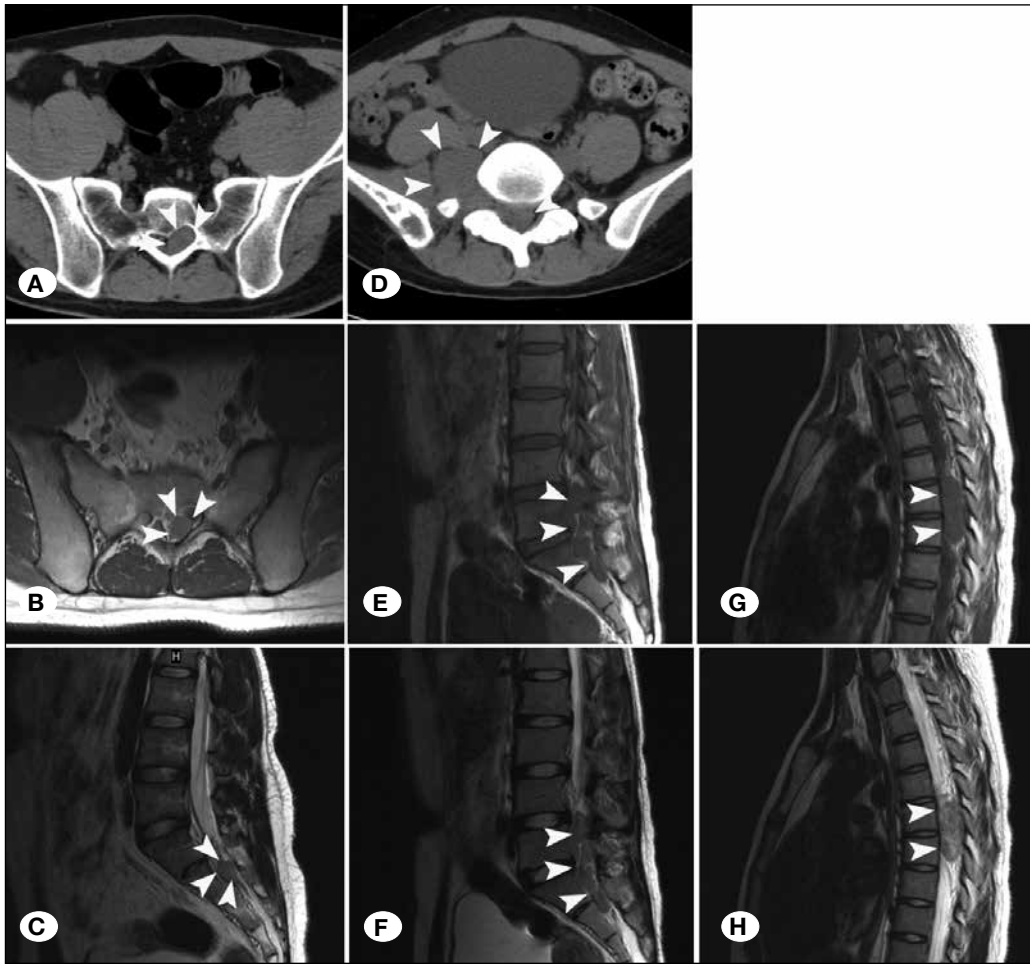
A) spPNET mass usually presents as an iso-dense mass on CT, an isointense signal on T1-WI, and a heterogeneous hyperintense signal on T2-WI. A, B, C) One extradural lesion (Case 2) at the S1 vertebral level (arrowheads). D, E, F) One intradural extramedullary lesion (Case 3) at the L5-S2 vertebral level (arrowheads). G, H) One extradural lesion (Case 1) at the T6-7 vertebral level (arrowheads).
